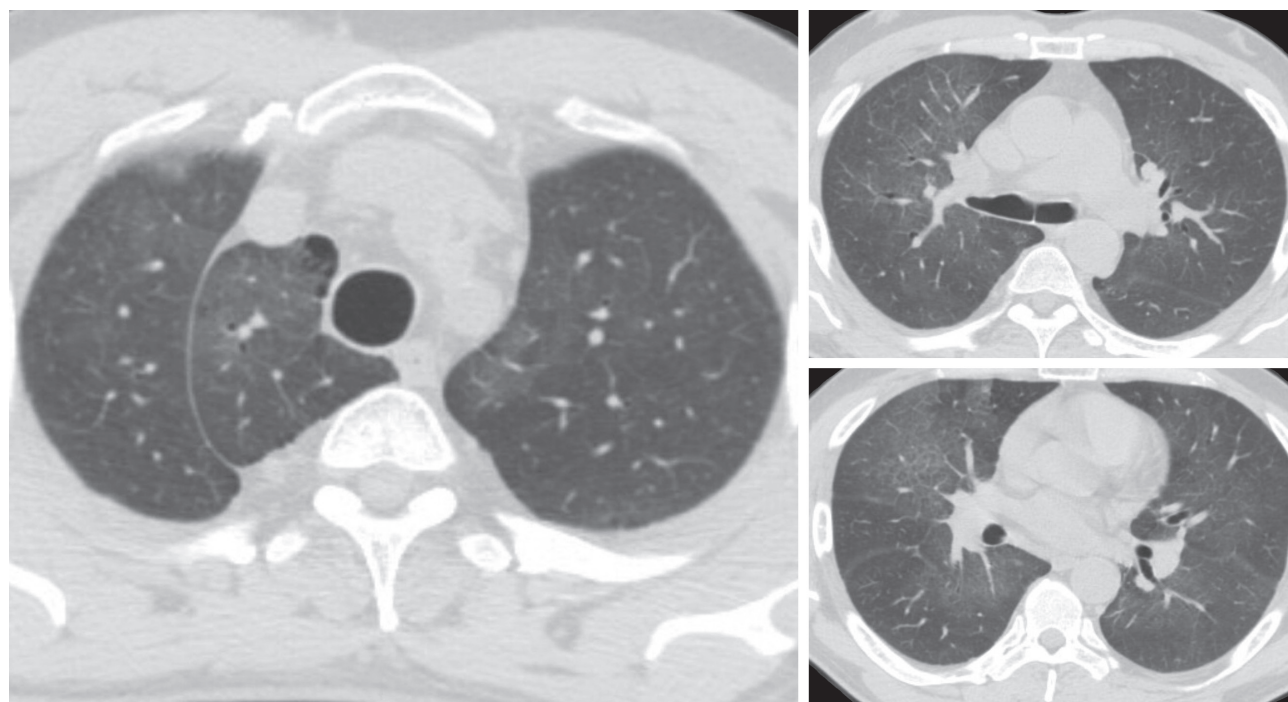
Chest CT at the Emergency Department showing bilateral ground glass opacification with peribronchovascular distribution predominant in the upper lobe
